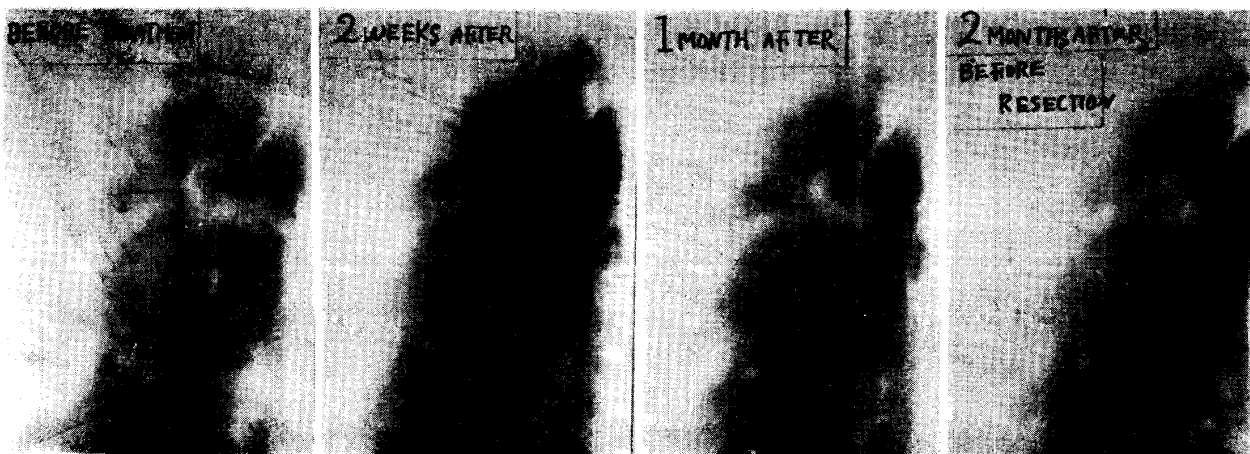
Change of chest radiograph of Case I after treatment.
